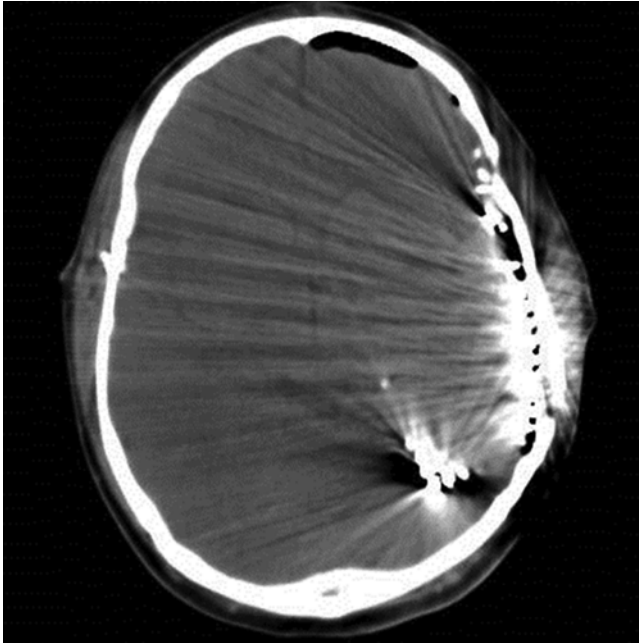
Significant brain compression from intracranial electrodes. An axial CT image obtained in a 26-year-old patient who developed persistent aphasia after electrode implantation presumably due to brain compression from the mass effect of the electrodes and cerebral edema. No hematoma was noted, despite the significant artifacts from the electrodes on the left side. Note that the bone flap was not elevated in this case.
